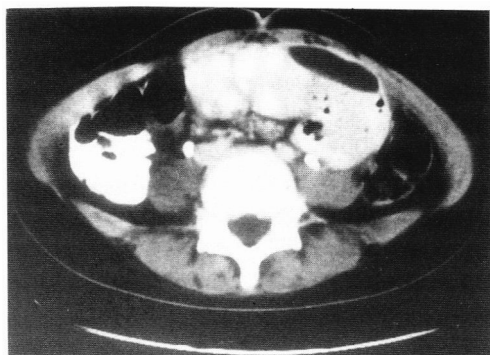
CT scan showing matted loops of small intestine and free fluid in the peritoneal cavity.
